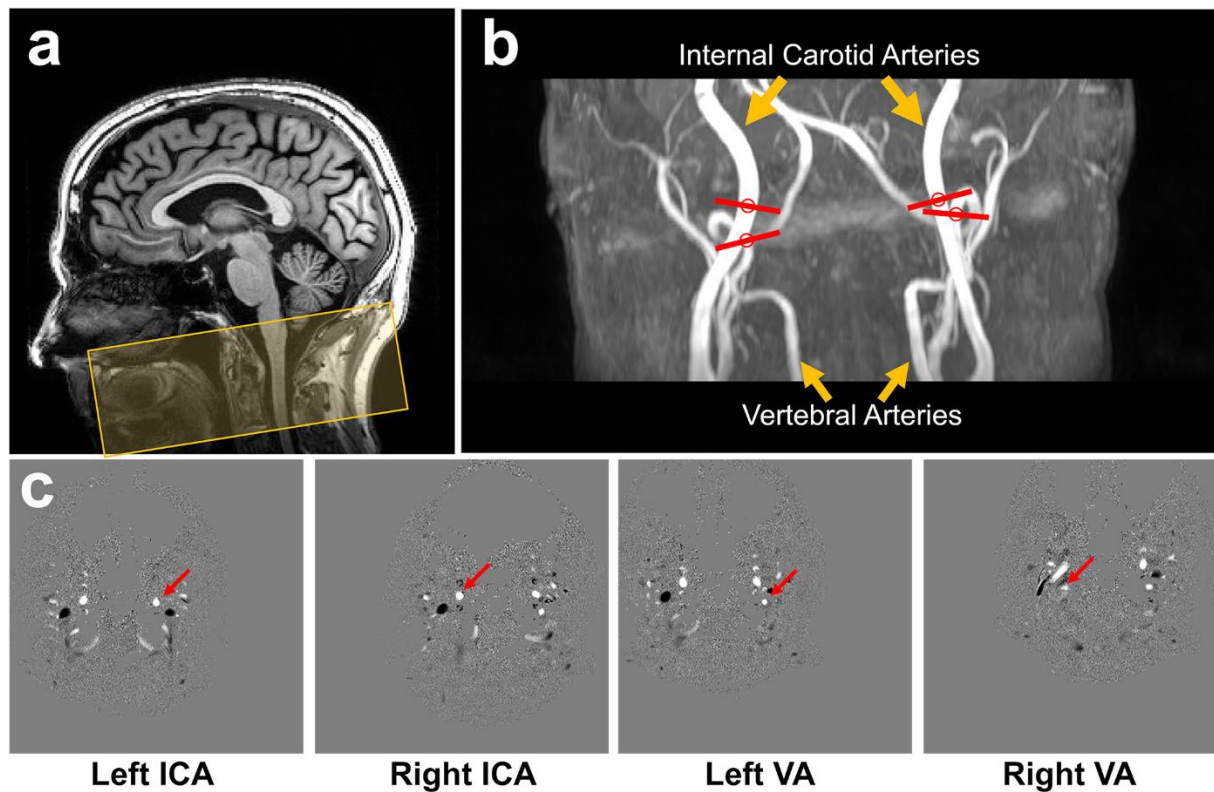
Measuring cerebral blood flow using phase-contrast MRI. From Han et al. (2022).
